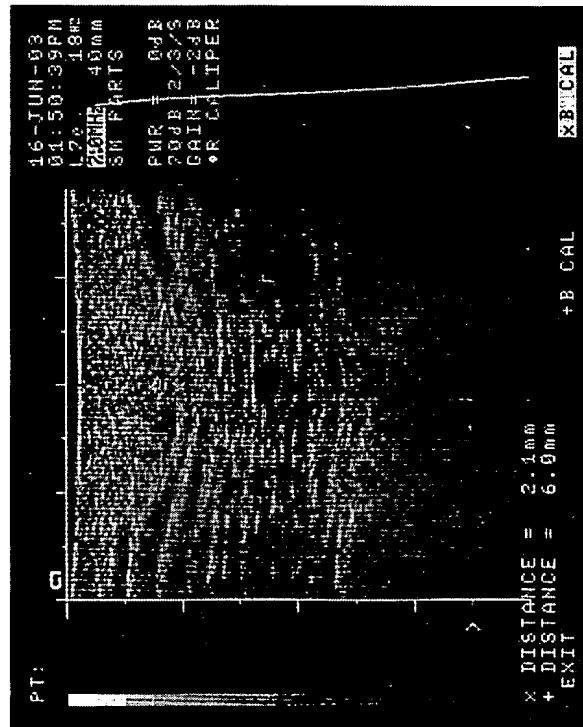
Versions of the ultrasonic scanning patterns of the B-16 cell culture injection site when the thickness of subcutaneous adipose tissue was up to 20 mm.
